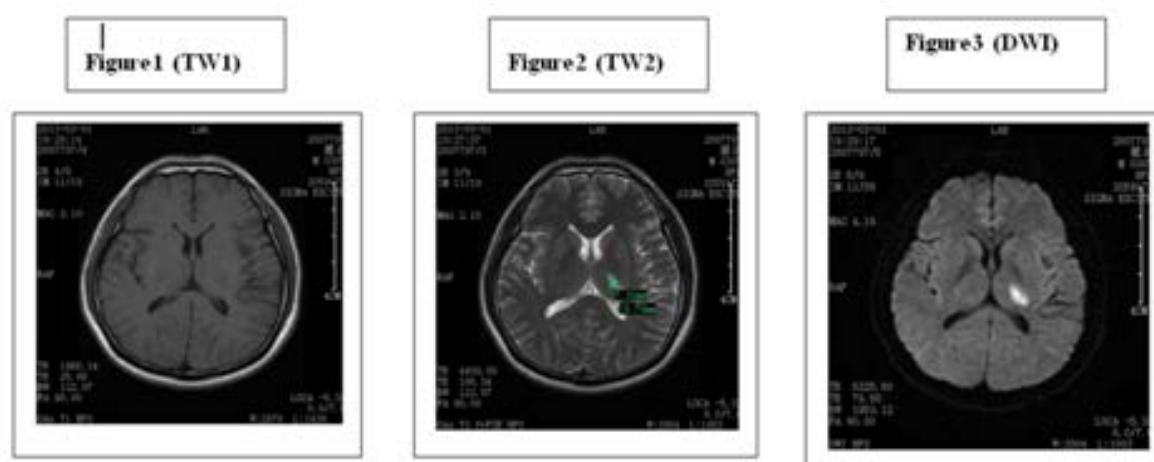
Cranial magnetic resonance: Figure 2 (T2-weighted) and Figure 3(diffusion weighted) reveals a focal high signal intensity change (19.78*7.32mm),suggesting a fresh lesions of infarction in left thalamus
